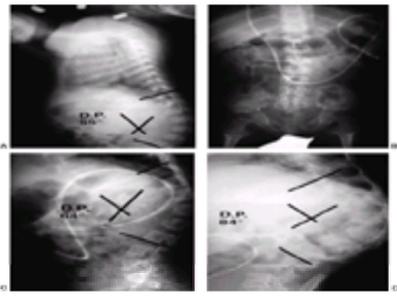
Achondroplastic dwarf with progressive thoracolumbar kyphosis. A: Lateral radiograph at 1 year of age shows a 55-degree thoracolumbar kyphosis. B: Anteroposterior radiograph at 5 years of age shows narrowing of the lumbar interpedicular distance characteristic of achondroplasia. C: Lateral radiograph at 5 years of age reveals a 64-degree kyphosis. D: Lateral radiograph at 9 years of age shows an 84-degree thoracolumbar kyphotic deformity.
